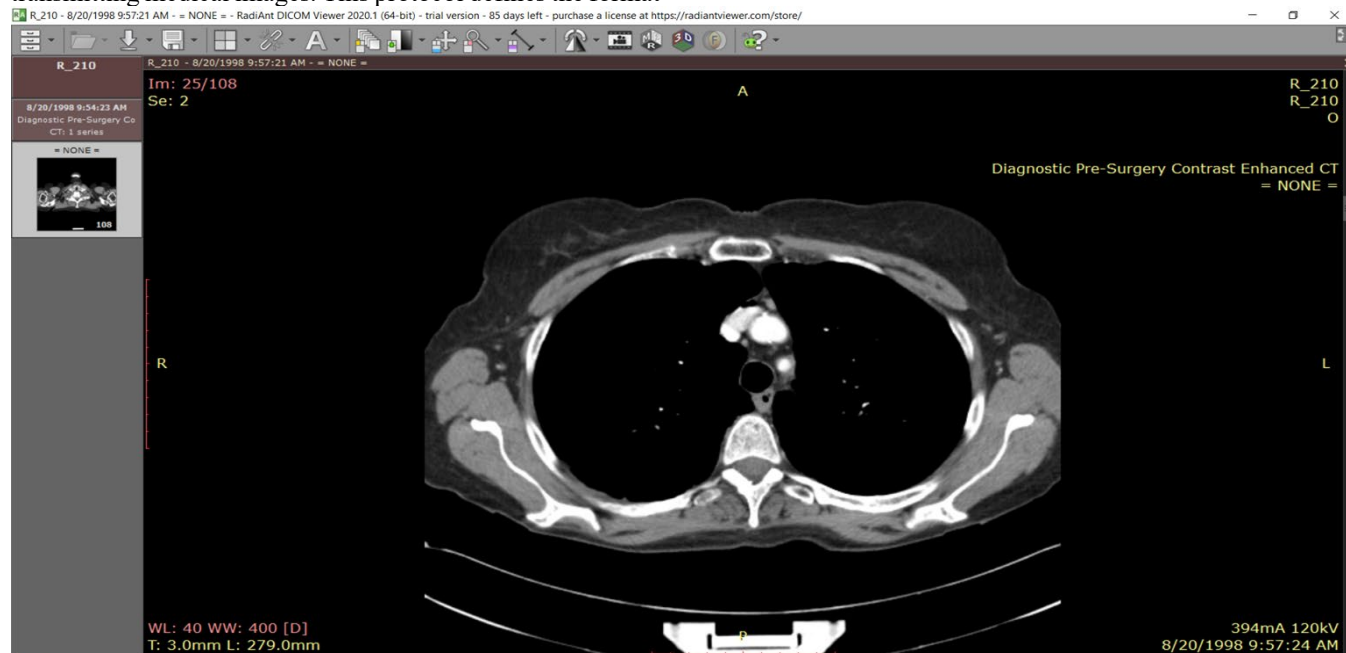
Visualization of a slice of CT scan of the subject R_210 showing raw metadata attached to it.
